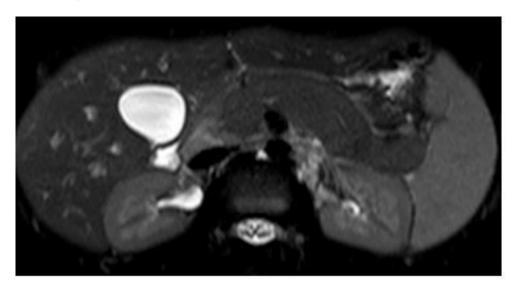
CT scan showing an enlarged pancreas with loss of lobulations.
